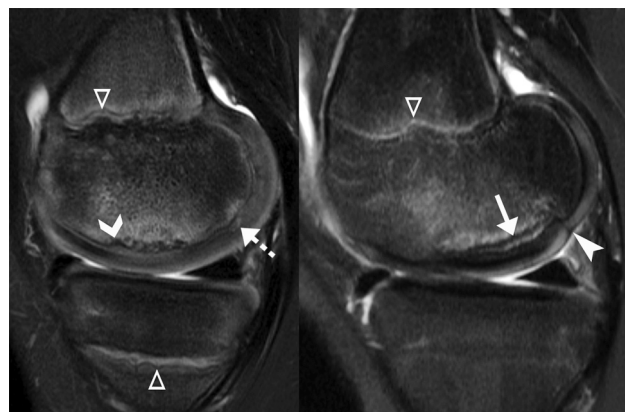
Examples of stable and unstable medial femoral condyle juvenile osteochondritis dissecans (JOCD) lesions. Sagittal T2-weighted fat-suppressed image from an 11-year-old boy (left) shows a stable JOCD with irregularity of the ossification front (chevron), perilesional marrow edema, and intact overlying cartilage. A normal ossification variant is identified within the posterior femoral condyle (dashed arrow). In contrast, sagittal T2-weighted fat-suppressed image from a 14-year-old girl (right) shows an unstable JOCD with focal hypointense full-thickness chondrosis (arrowhead) and disruption of the radius of curvature. Other findings include high (but not fluid-high) signal intensity interface, marginal sclerosis of the parent bone (arrow), and perilesional marrow edema. Note the open regional physes (triangles) reflecting skeletal immaturity of the 11-year-old boy and impending maturity of the 14-year-old girl.
